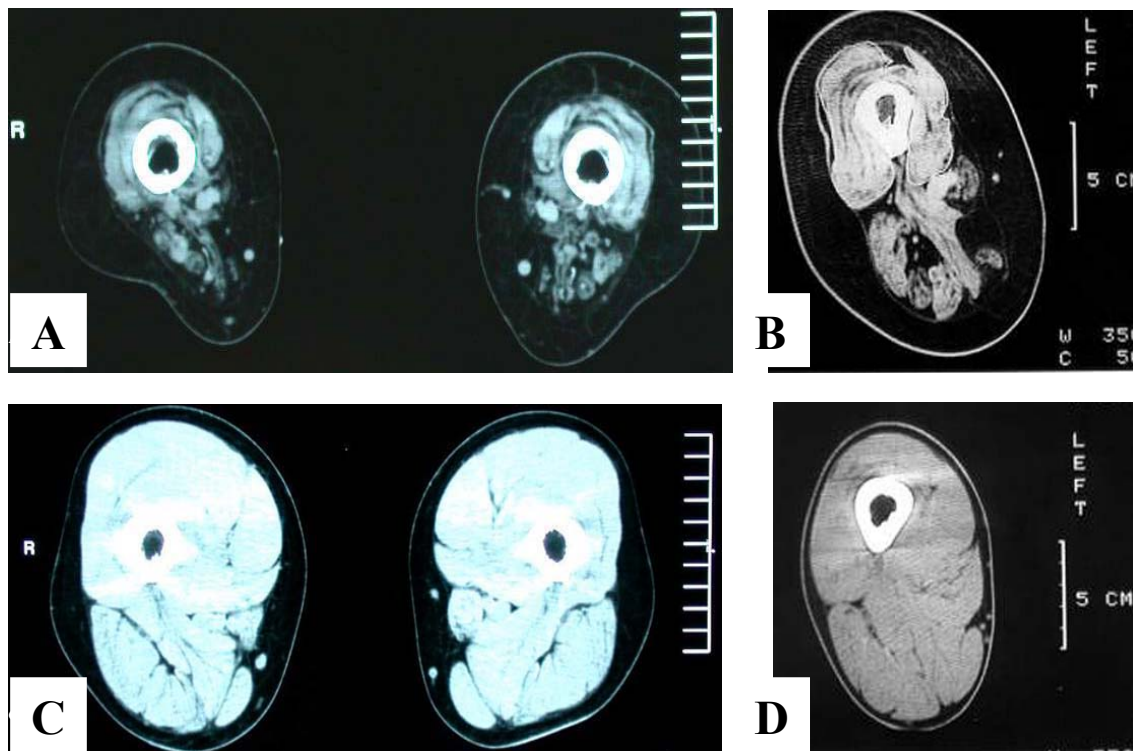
CT-Scans cross-section of the thighs of two long term denervated patients without stimulation (A, B), of a long term denervated patient with stimulation (C) and of a patient with a spastic lesion and stimulation (D).
